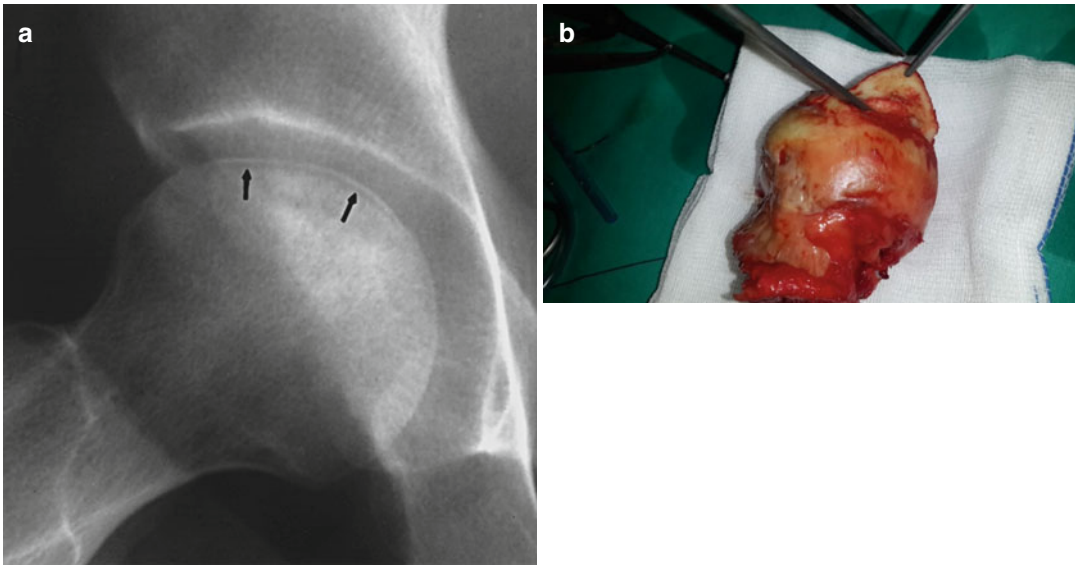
Separation of subchondral bone (*crescent sign*). (a) X-ray (*arrows*) and pens show the separation of subchondral bone. (b) Intraoperative photo
